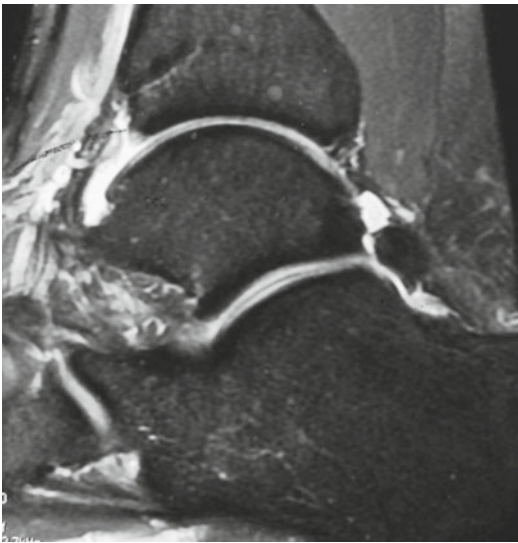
MR image of an os trigonum which causes no pain, no complain
